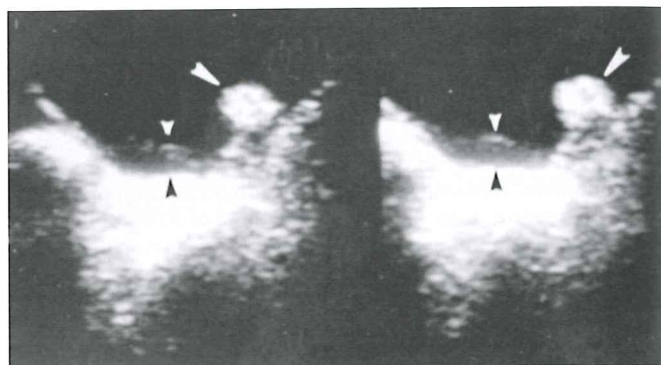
Urinary schistosomiasis. Ultrasonographic view of bladder. Thickening and irregularity of the bladder wall (small arrows) and a large polyp (large arrows) are present.
